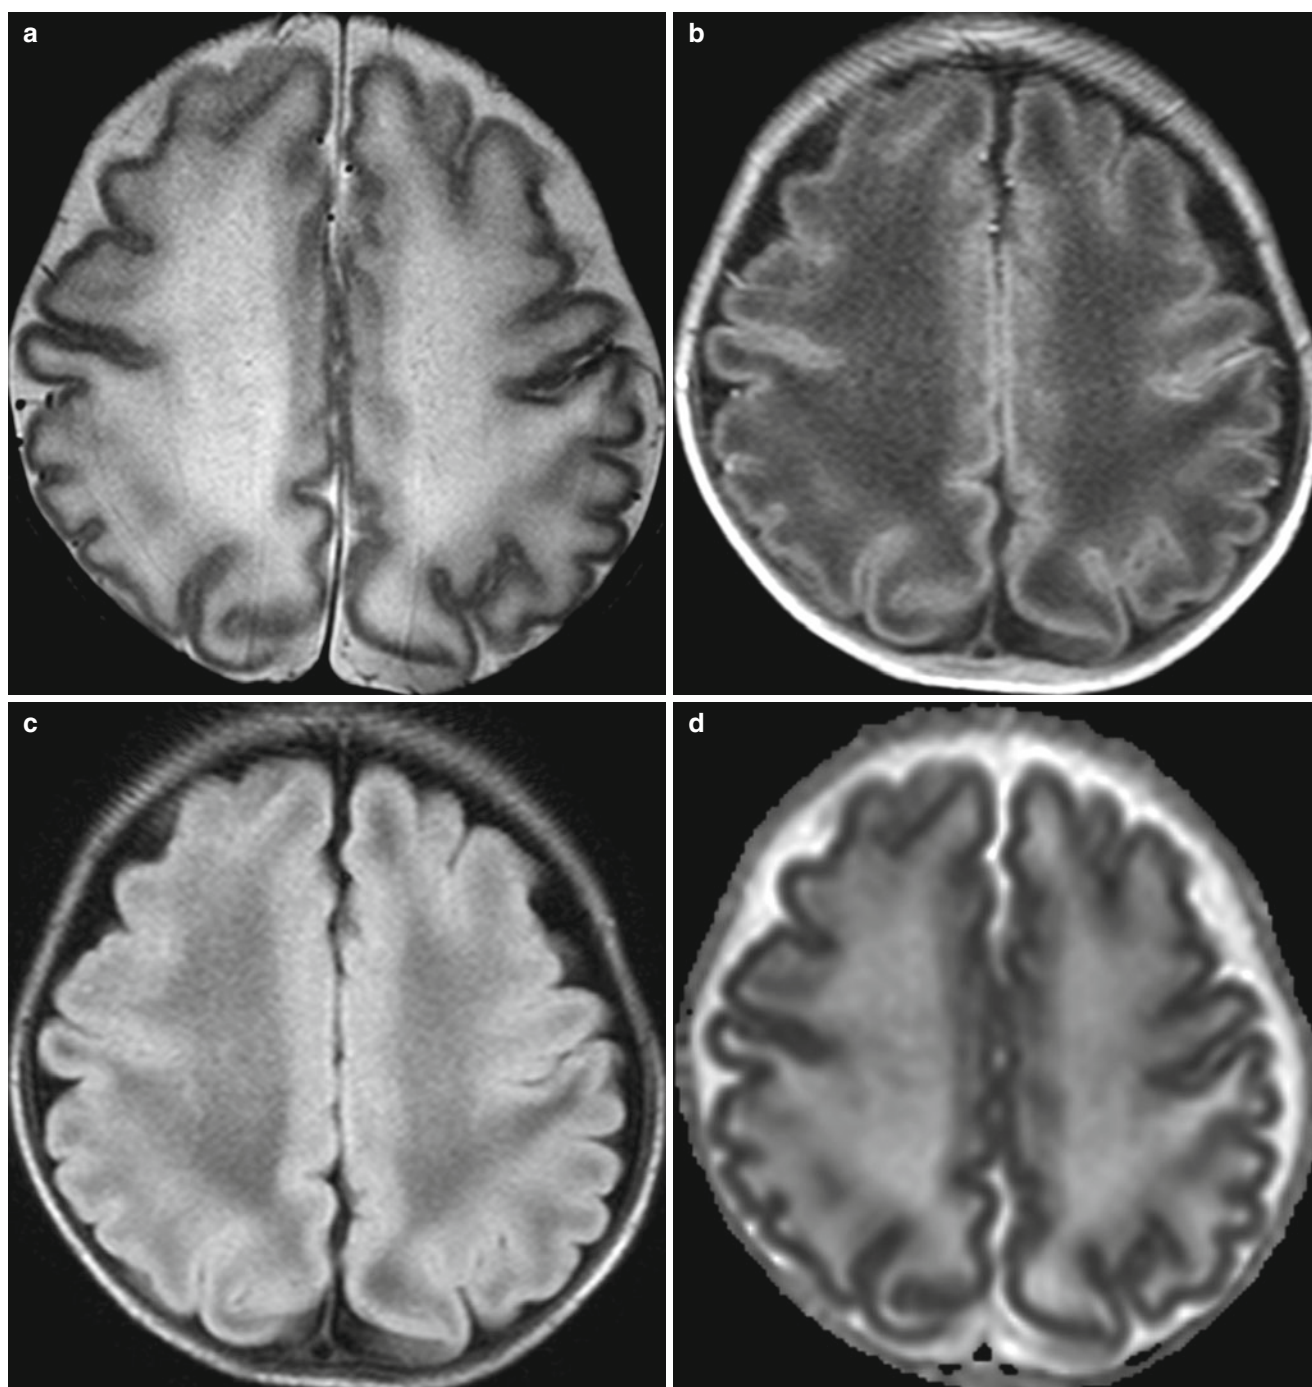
Diffuse excessive high signal intensity (DEHSI) in preterm baby at corrected gestational age of 36 weeks. (a) T2-weighted axial image shows excessive higher signal intensity of the centrum semiovale
